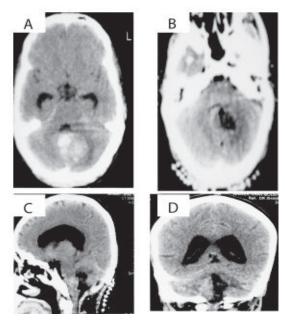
(Case 4): PreoperativeCT Scan(A,C) and immediate postoperative CT scan(B,D)of same patient showing no residual cavernous angioma.
